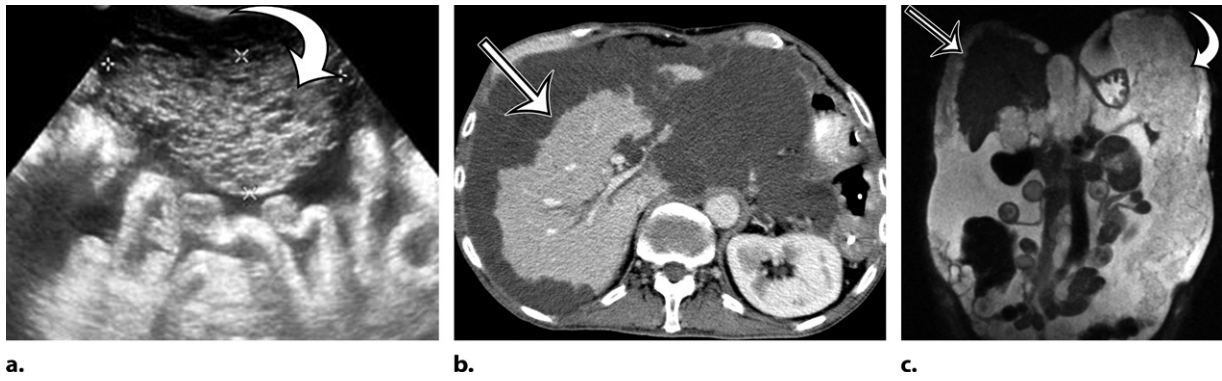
PMP in a 57-year-old man. (a) Sagittal US image shows masslike expansion of the omentum with echogenic septa (arrow) surrounded by hypoechoic gelatinous fluid. The subjacent bowel loops are displaced centrally. (b) Axial contrast-enhanced CT image shows low-attenuation fluid surrounding the liver and displacing the stomach, with scalloping of the hepatic surface (arrow), which represents extrinsic pressure from the mucinous implants. (c) Coronal T2-weighted image shows scalloping of the intraperitoneal visceral surfaces (straight arrow) and heterogeneous signal intensity of the fluid (curved arrow), which allow differentiation of PMP from simple ascites.
